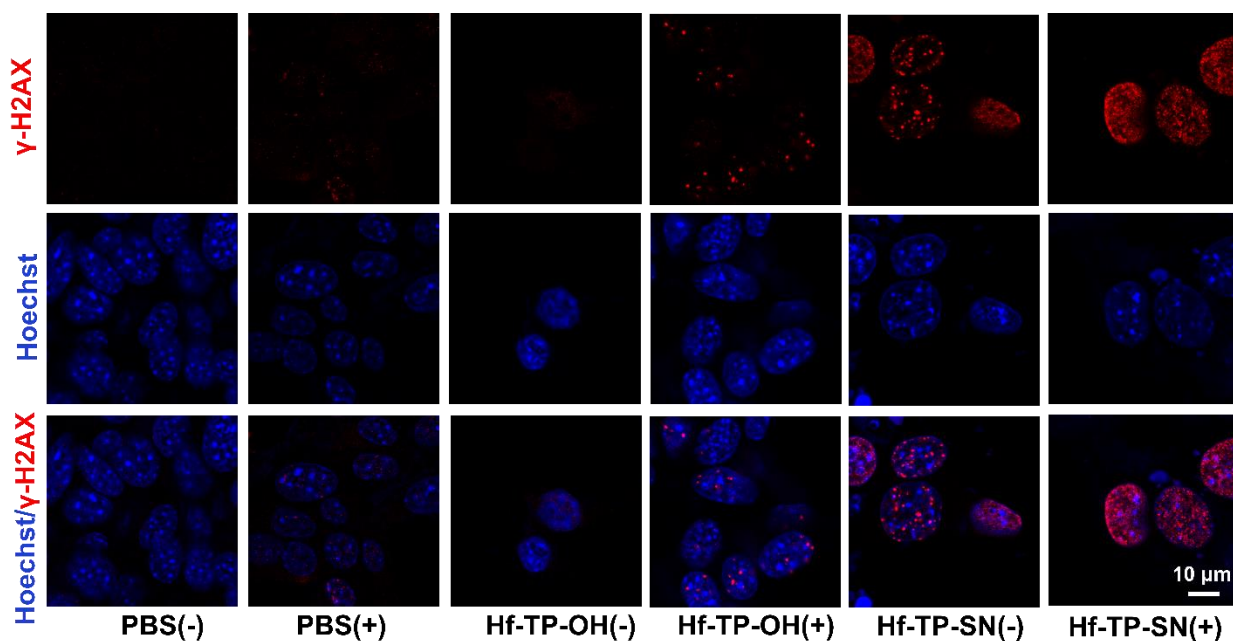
CLSM images of CT26 cells for γ -H2AX assay, (scale bar: 10 μ m). X-ray dose: 3Gy.
